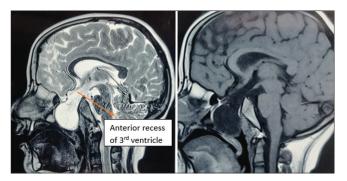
Sagittal section T2 and T1 sequences of magnetic resonance imaging showing herniating meninges through the sellar floor into the sphenoid sinus, including anterior recess of third ventricle, with no separately identifiable pituitary gland and stalk.
